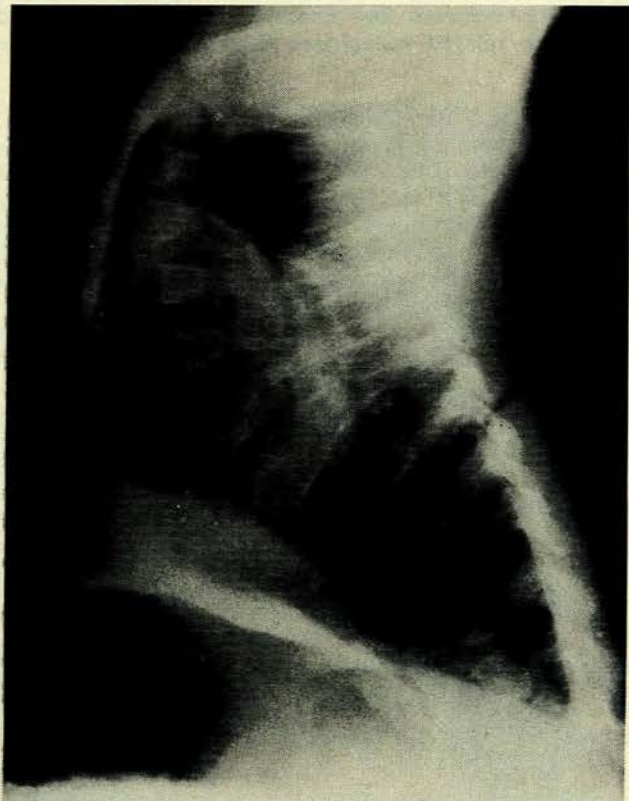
Lateral chest X-ray revealing hypoplasia of the anterior part of the ribs and club-shaped costochondral junctions.
